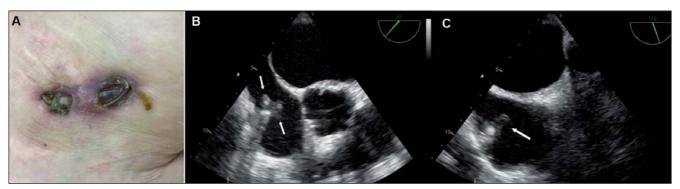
(A) Infection of pacemaker's pocket with externalization of the two catheters. (B and C) Transoesophageal echocardiogram confirming the presence of several mobile vegetations adherent to both the leads.
